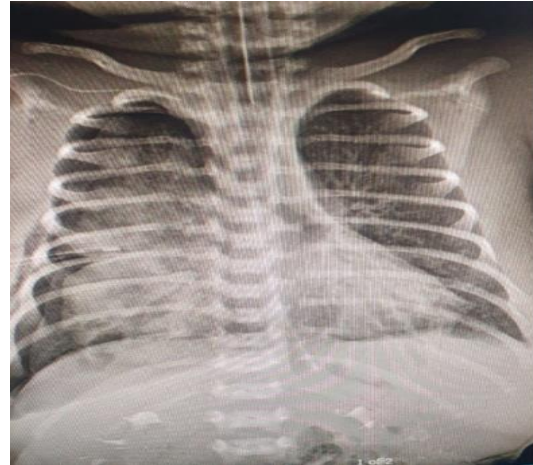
The X-ray image shows the respiratory distress syndrome (RDS) and pneumothorax in the 2nd day of life with visible shadows of tube, intrathoracic drain and central venous catheter on the right side.
